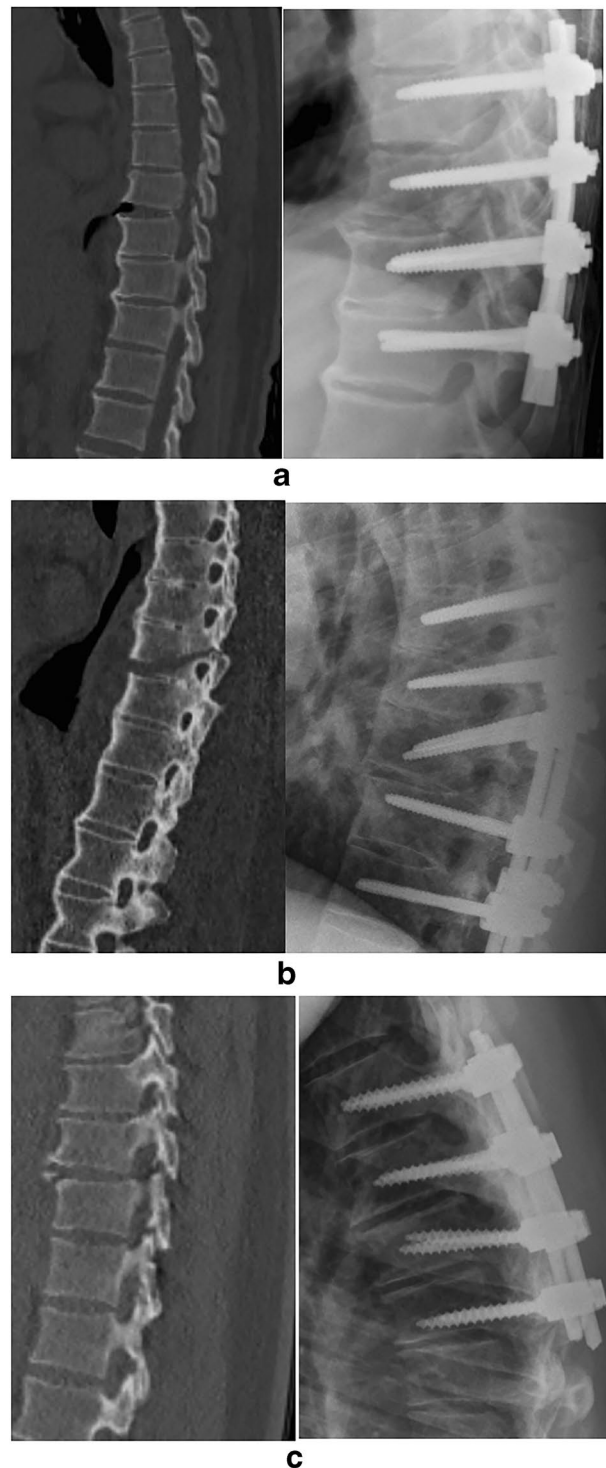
Sagittal CT image of the spine with type B3 fractures in DISH (A), AS (B), and NAS (C) and lateral radiographs
